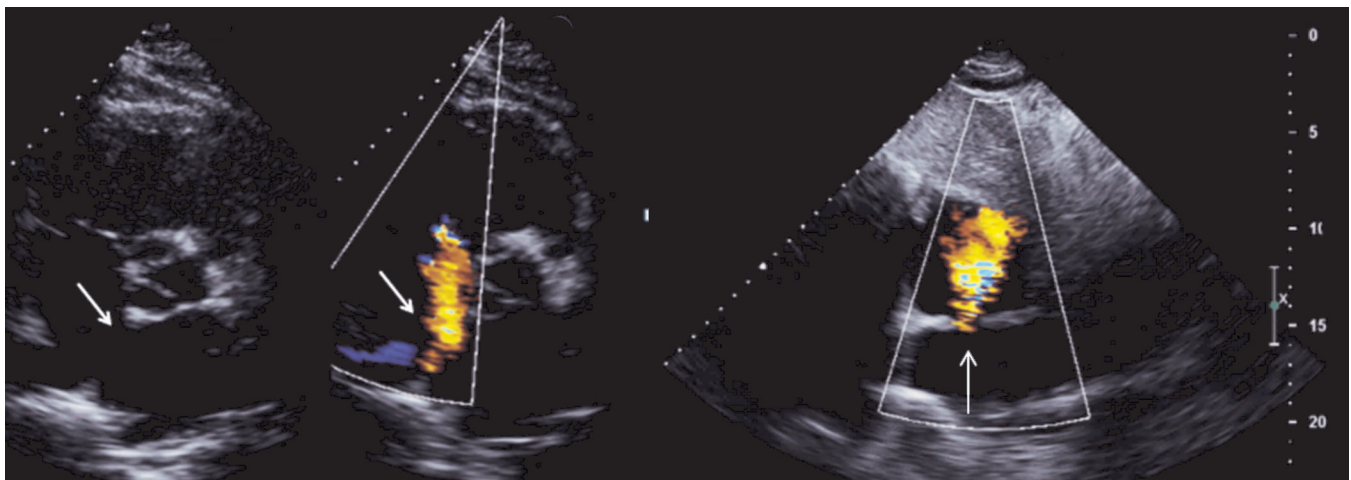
Parasternal (left and middle panels) and subcostal (right panel) images of a secundum ASD and its associated left-to-right shunt (arrows).
